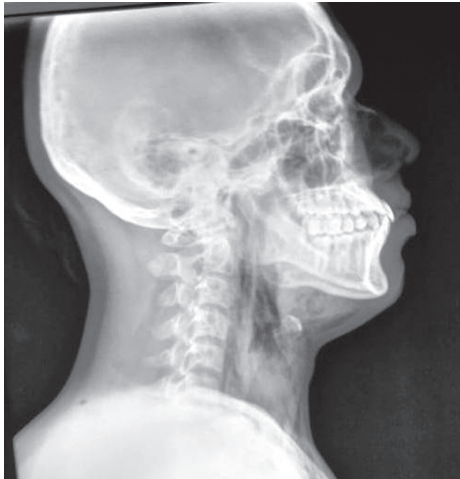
X-ray neck lateral view showing subcutaneous emphysema
